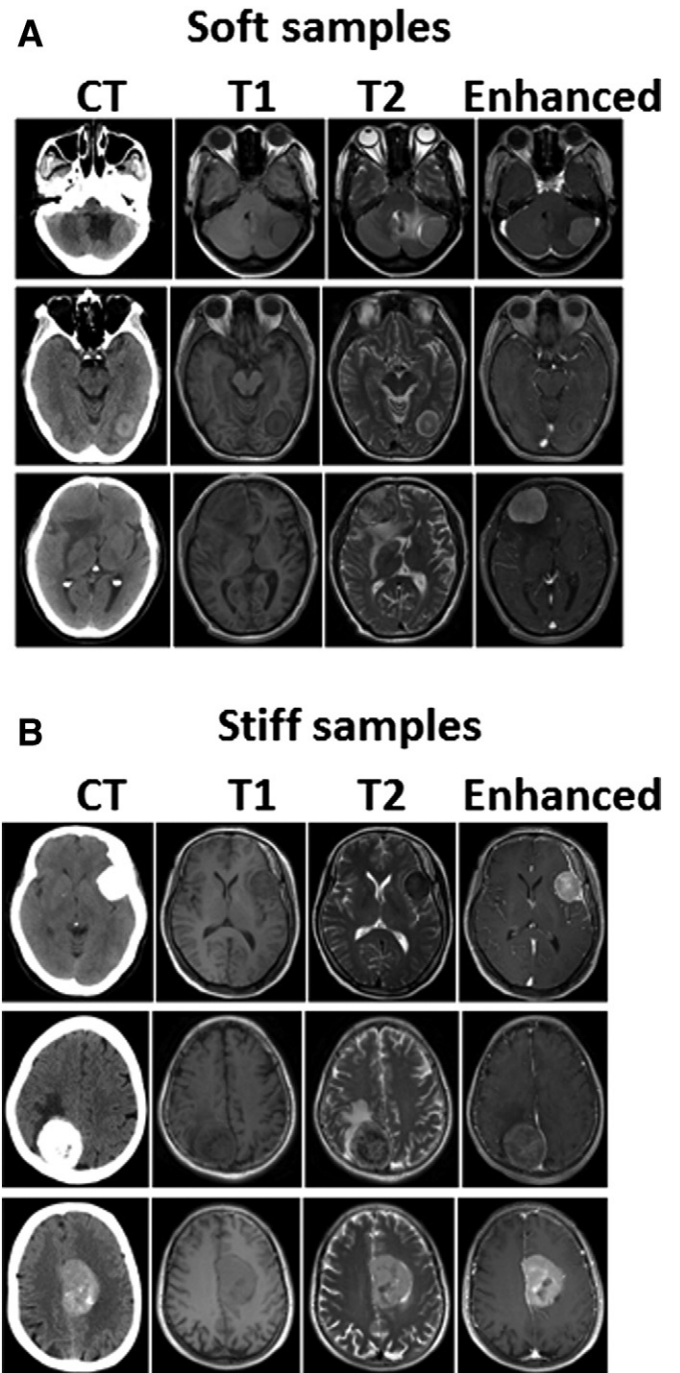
The computed tomogram (CT) and magnetic resonance imaging (MRI) images representing soft texture (A) and firm texture (B) samples from meningioma patients. From the computed tomogram (CT) images, we can see the hard meningiomas were obviously calcified.
